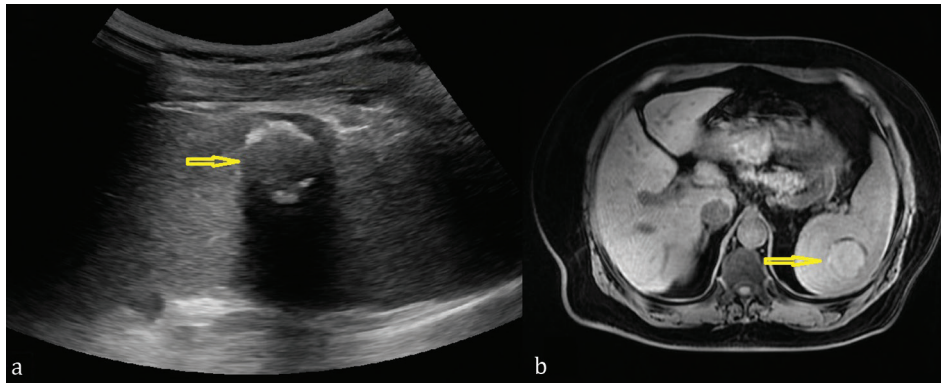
Splenic Gaucheroma: a) ultrasound image; b) MRI appearance.
